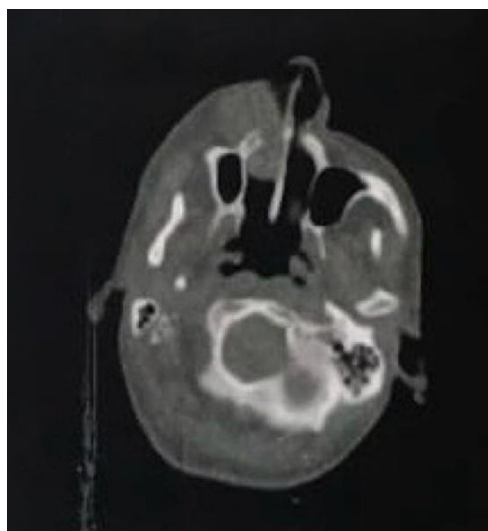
Axial CT scan showing an osteolytic mass of the right maxilla
